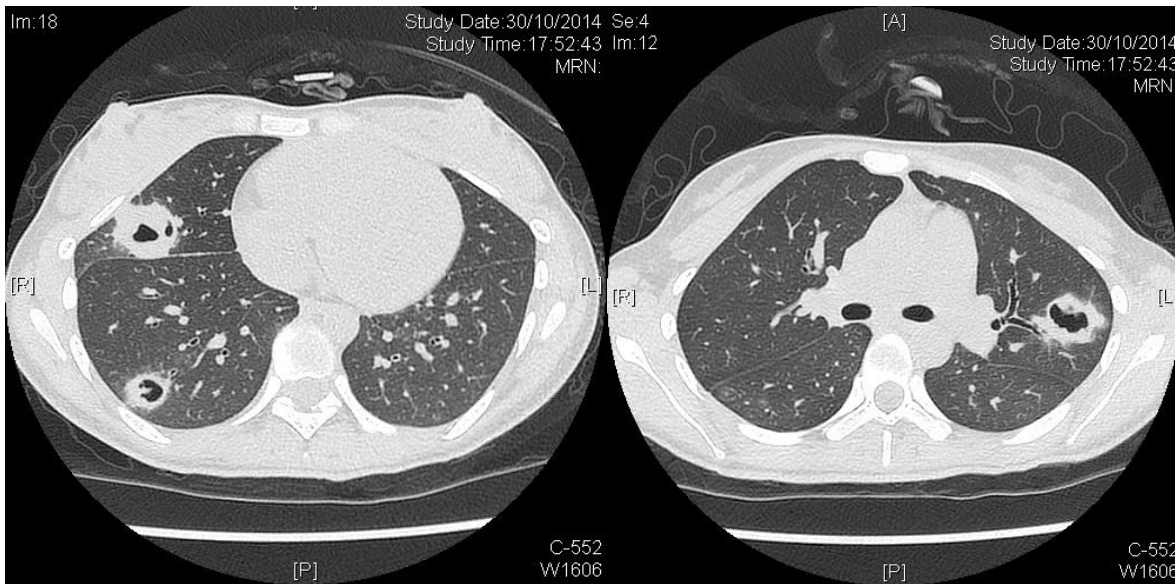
CT thorax demonstrated cavitary lesions of variable sizes involving all the lung lobes with fluid levels for the one at RUL.
